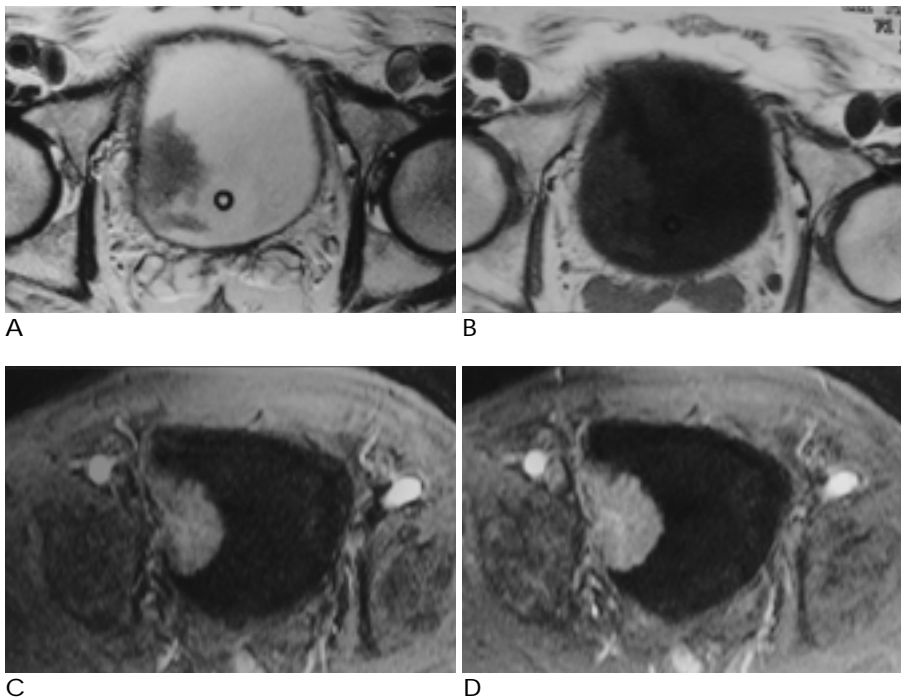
Transitional cell carcinoma of the bladder, stage pTIIla. Axial T2-weighted image (A), axial T1-weighted image (B), arterial phase of Gd-enhanced dynamic image (C), and capillary phase of Gd-enhanced dynamic image (D) show a protruding mass in the right wall. Tumor invades muscle layer in full thickness. Perivesical extension is not demonstrated on T2WI, T1WI and dynamic MR image.
